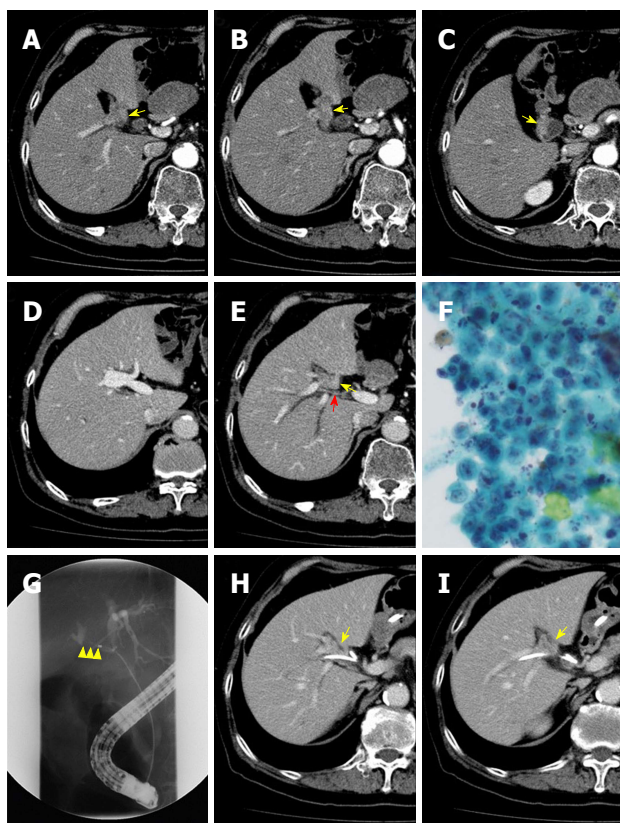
Contrast-enhanced computed tomography, cytological examination of bile, and endoscopic retrograde cholangiography. A, B and C: The highly atrophied gallbladder (yellow arrow) had tumor-like localized wall thickness enhanced by contrast medium; D: The cul-de-sac of the right-sided umbilical portion is shown; E: The gallbladder (yellow arrow) is located on the left-sided liver bed. Direct infiltration of the tumor into the right hepatic artery (red arrow) is not evident; F: Cytological examination of bile obtained from endoscopic retrograde gallbladder drainage demonstrated atypical cells with a high nucleo-cytoplasmic ratio, strongly suggesting adenocarcinoma; G: Endoscopic retrograde cholangiography shows severe stenosis of the right hepatic duct (yellow arrowhead); H and I: The gallbladder tumor (yellow arrow) directly spreads to the nearby right hepatic duct where an endoscopic nasobiliary tube was placed.
